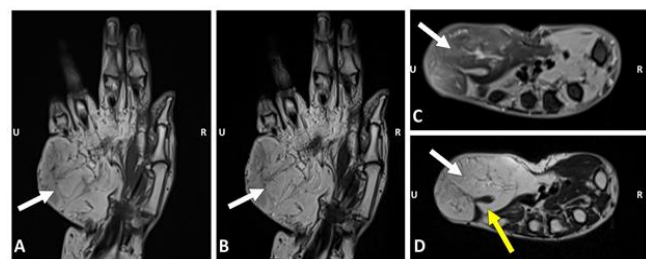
MRI of the right hand. (A) T1-weighted coronal image showing a well-defined hyperintense mass in the hypothenar region. (B) T2-weighted coronal image also showing a well-defined hyperintense mass. (C) Fat-saturated axial T1 image confirms fat signal suppression, consistent with lipoma. (D) T2-weighted axial image showing high signal and intermuscular extension. White arrow - shows lesion of interest in figures A to D. Yellow arrow - shows intermuscular extension of the lesion in figure D. MRI - Magnetic Resonance Imaging. R - Radial side. U - Ulnar side.
